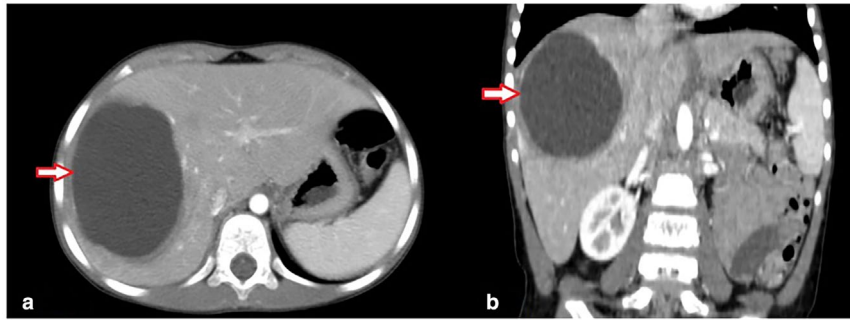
Axial (a) and coronal (b) view of Contrast-enhanced CT scan show a non-enhancing hepatic cyst in the right liver lobe. No evidence of biliary duct dilation and ascites, and right pleural effusion are observed.
